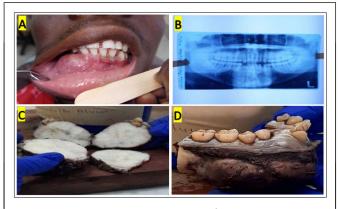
A: Physical appearance of patient with mass on the right lower mandibular; B: The radiograph reveals an increase multilocular radio- lucency image in right mandibular; C and D: Completely excised nodular mass measuring 9 cm \times 6 cm \times 5 cm in dimensions, hard in consistency, good excisional margins. Tumor growth was inside and outside of the mandibula. Cut surface of the tumor showing a white in color, with focal calcification area, no cystic area seen, no necrosis and no hemorrhage seen.
